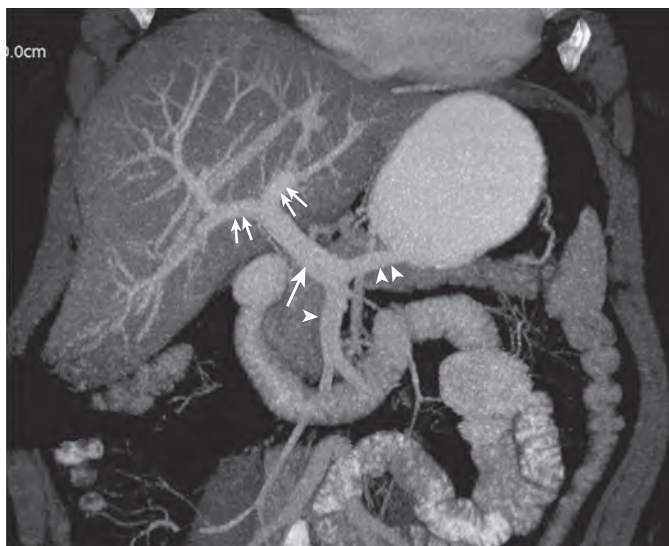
Portal venous anatomy. Maximum intensity projection image of CT of upper abdomen demonstrates confluence of superior mesenteric vein (single arrowhead) and splenic vein (double arrowheads) forming main portal vein (arrow). The main portal vein divides into right and left branches (double arrows) at the porta.
